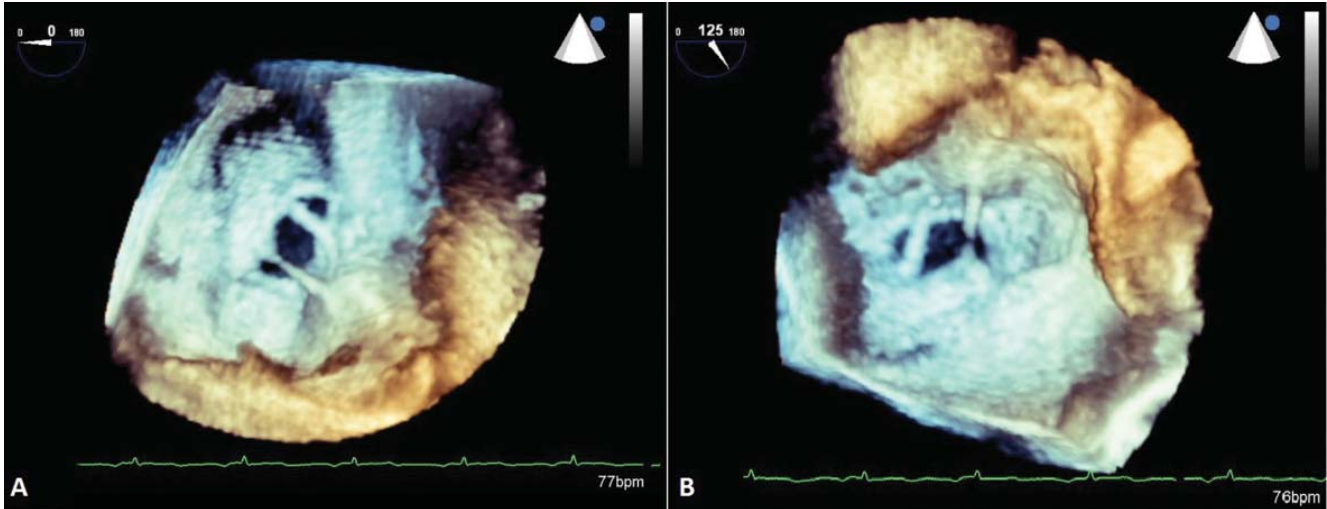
Real-time three-dimensional transesophageal echocardiography showing the complex nature of the septum and providing accurate images of multiple defects separated by two bands of interatrial septum from two different aspects (A and B).
